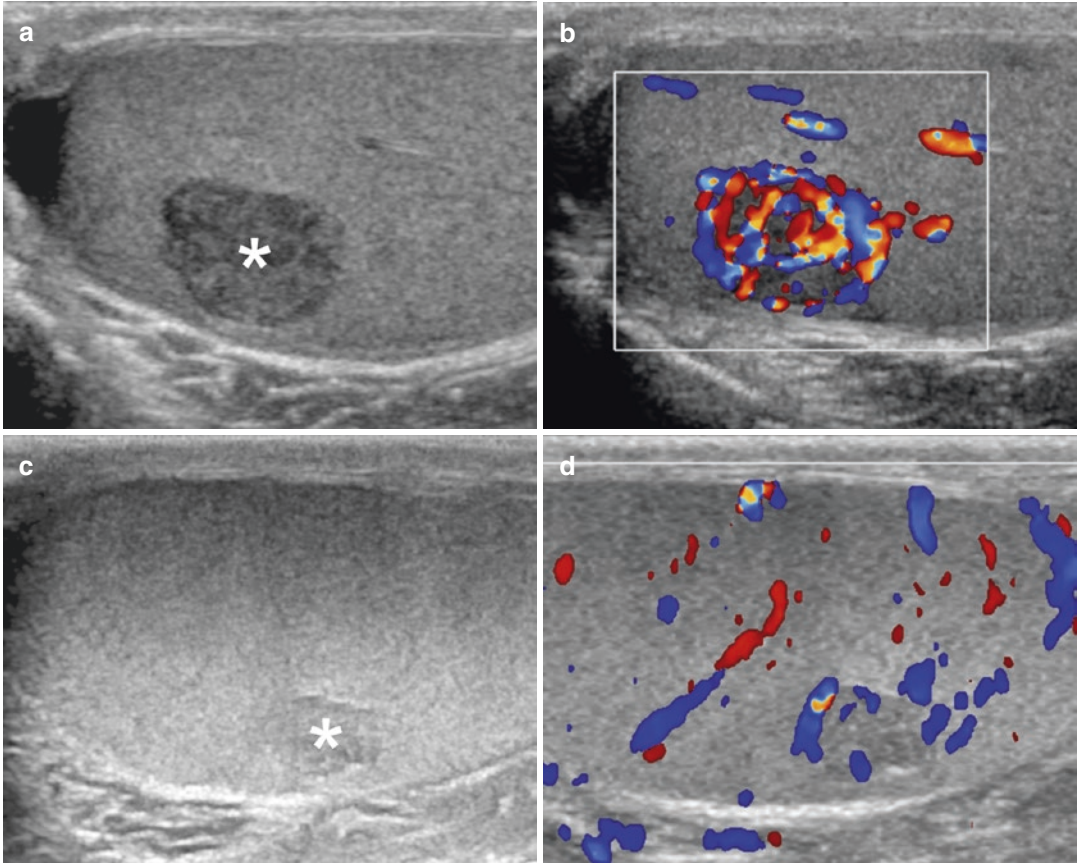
Two different patients with Leydig cell tumors. (a, b) Hypoechoic nodule displaying marked vascularization at color Doppler interrogation. (c, d) Nearly isoechoic
